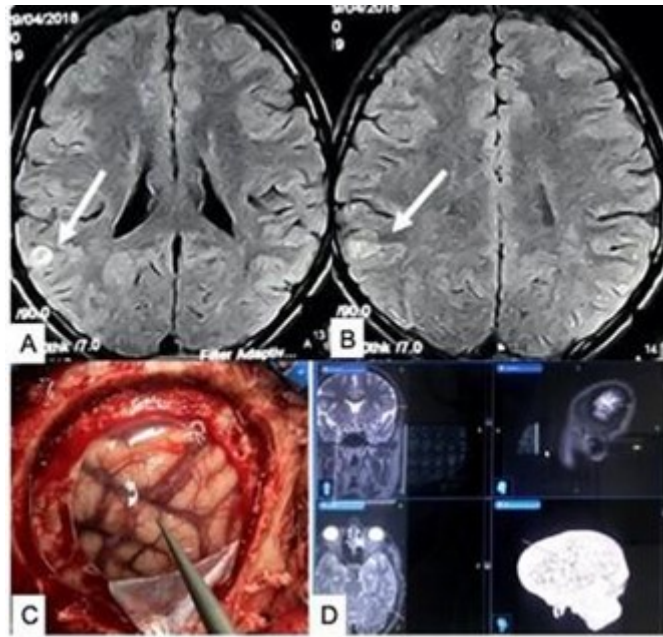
(A,B) MRI of brain axial sections showing right parietal small FCD. (C,D) Peroperative identification of lesion with neuronavigation guide. Source: Figure by authors.
